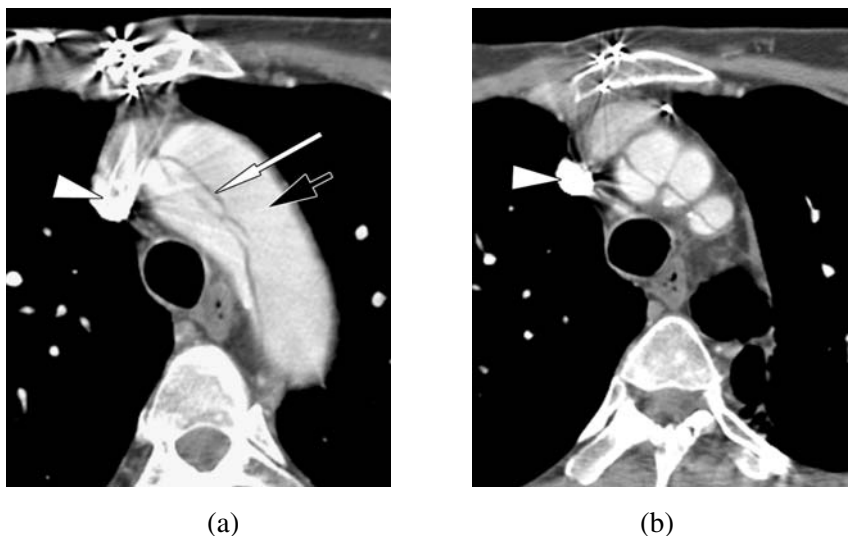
Axial contrast-enhanced CT images of classic type A dissection in a patient with prior sternotomy: (a) shows dissection flap in the aortic arch (long white arrow) (the false lumen is indicated by the short black arrow); (b) shows extension of the dissection flap into the brachiocephalic arteries (the flap does not occlude those branches, and perfusion is not impaired); streak artifact from metallic sternotomy wires and concentrated contrast in the superior vena cava (white arrowhead) is also demonstrated.
